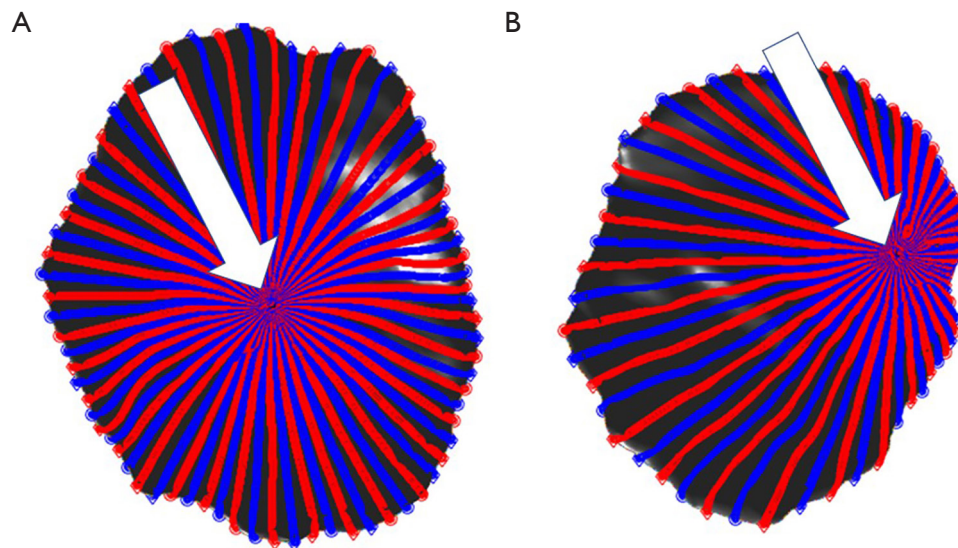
Three-dimensional reconstructions of *in vivo* placentas from MRI images, with the cord insertion site highlighted by a white arrow. Panel (A) demonstrates a placenta with central cord insertion site, and relatively symmetric fetal surface radii, while Panel (B) demonstrates a placenta with eccentric cord insertion site, and asymmetric fetal surface radii. These metrics have been used to develop a cord centrality score (unpublished data), as eccentric cord insertion sites are associated with growth disturbances of both the infant and placenta.
